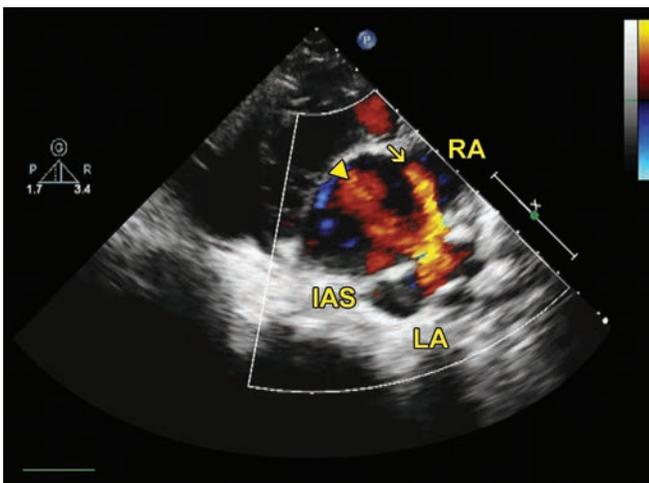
Right parasternal approach. Two jets (arrowhead and arrow) are seen in the RA, one of which could be flow from an anomalous pulmonary vein and the other the sinus venosus shunt.
